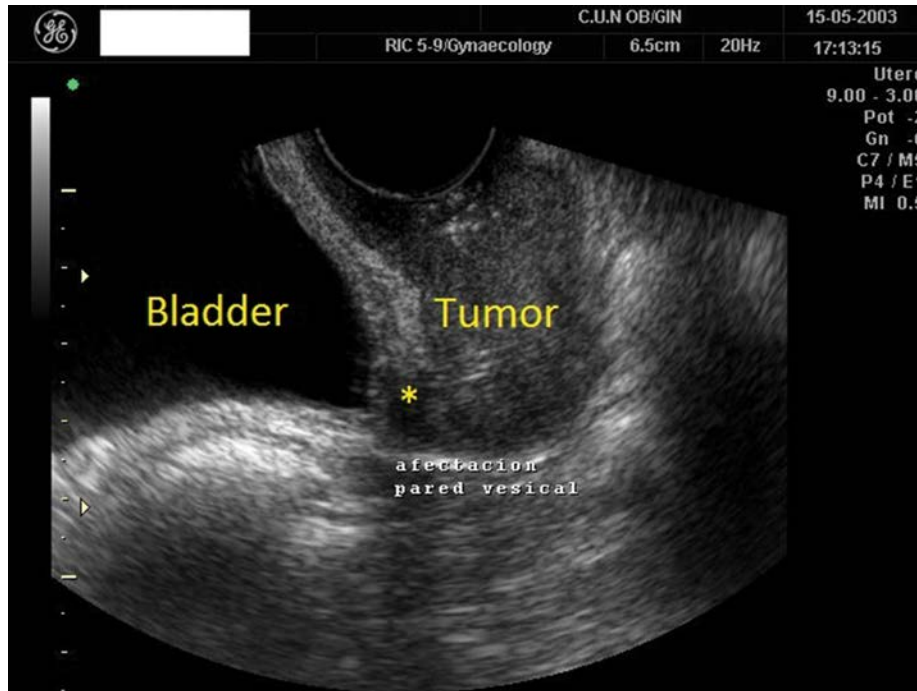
Transvaginal ultrasound in a case of vaginal carcinoma. Sagittal view. Bladder infiltration is suspected (*).
